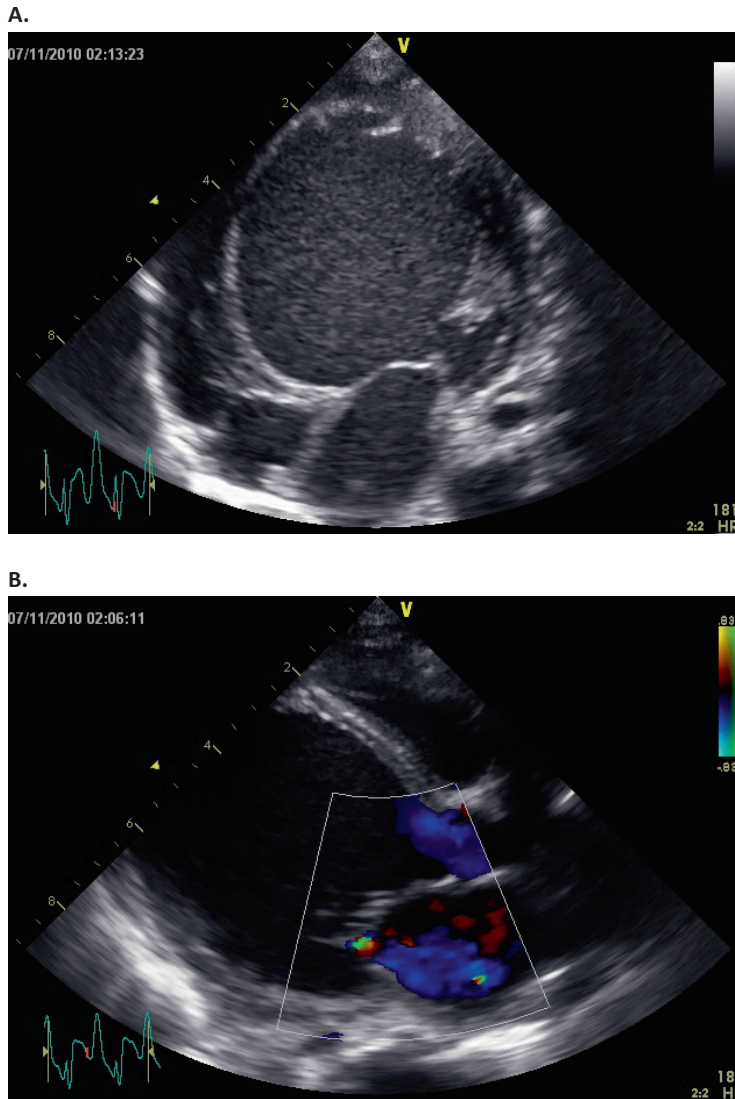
Echocardiography showing a profound dilatation of the left ventricle (A, B) and mitral regurgitation (B).
